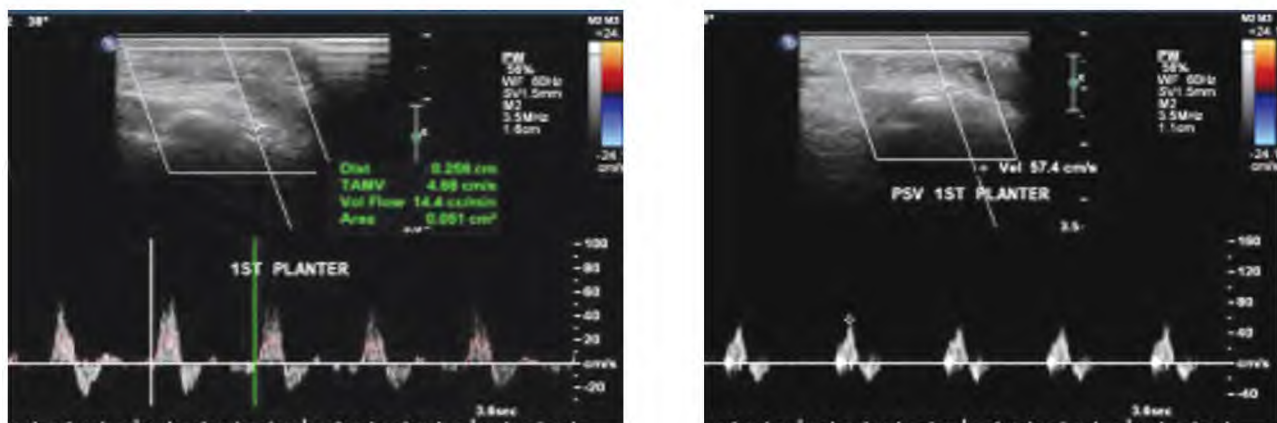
(A): Doppler ultrasound view showing the volume flow rate in the first plantar metatarsal artery.
